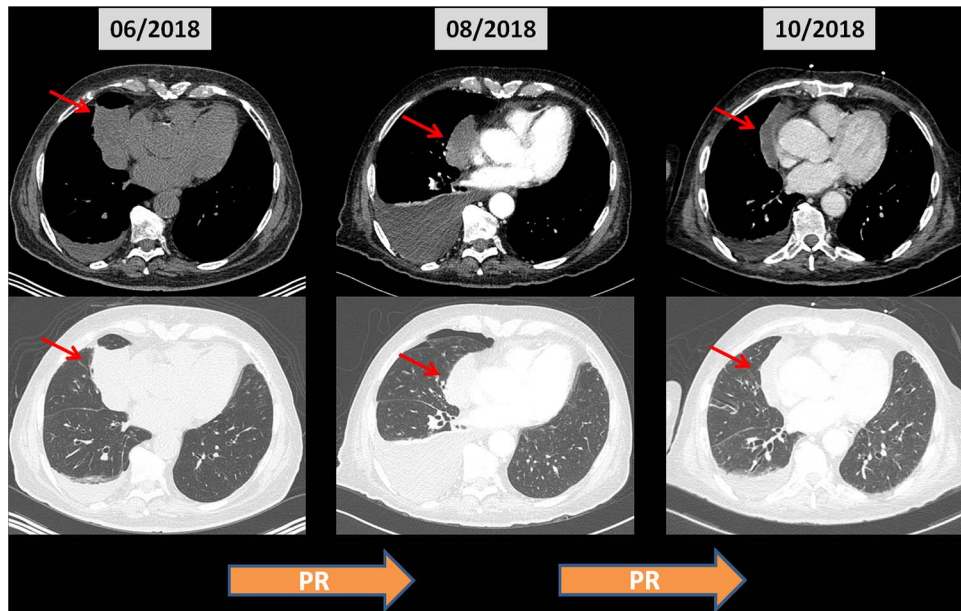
Chest CT demonstrating progressive response after initiating immunotherapy, with reduction of middle lobe pulmonary mass (red arrow).
